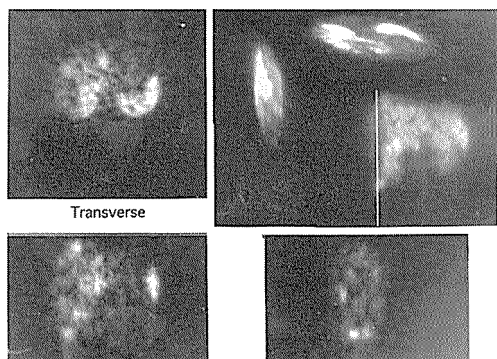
¹¹¹In-octreotide SPECT of the liver. Transversal, coronal and sagittal slices. Multiple liver metastases in patient with bronchial carcinoid.
